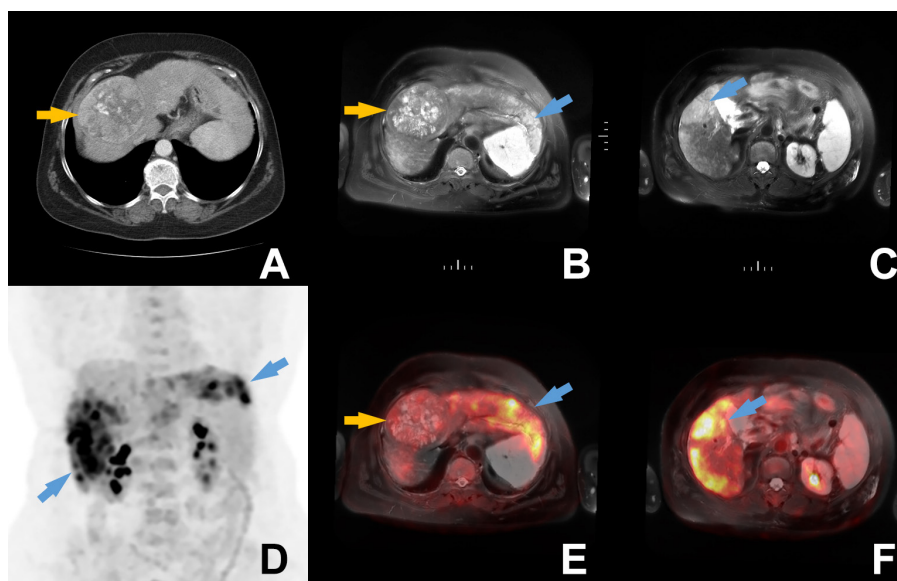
A 73-year-old woman with hepatitis B infection presented with abdominal pain and dynamic liver computed tomography (CT) revealed a 9 cm lesion in the liver (A, orange arrow). The patient's serum alpha feto protein (AFP) levels were measured as high as 60,500 ng/mL. The patient was referred for ^{18}F -fluorodeoxyglucose positron emission tomography/CT (^{18}F -FDG PET/CT) and magnetic resonance imaging (MRI) for staging of probable hepatocellular carcinoma (HCC) diagnosis. However, ^{18}F -FDG PET/CT and MRI revealed diffuse infiltrating HCC lesions in both lobes of liver in addition to the previously defined 9 cm mass. The diffuse infiltrating lesions (blue arrows) were hyperintense in axial T2-weighted MRI (B, C) images and showed intense ^{18}F -FDG uptake with maximum standardized uptake value (SUV_{max}): 12.5 as visualized in the maximum intensity projection (MIP) (D), axial PET/CT MRI fusion images (E, F). Additionally, the previously defined 9 cm lesion (orange arrows) had very mild ^{18}F -FDG uptake. Sorafenib treatment was initiated after the detection of advanced disease.
